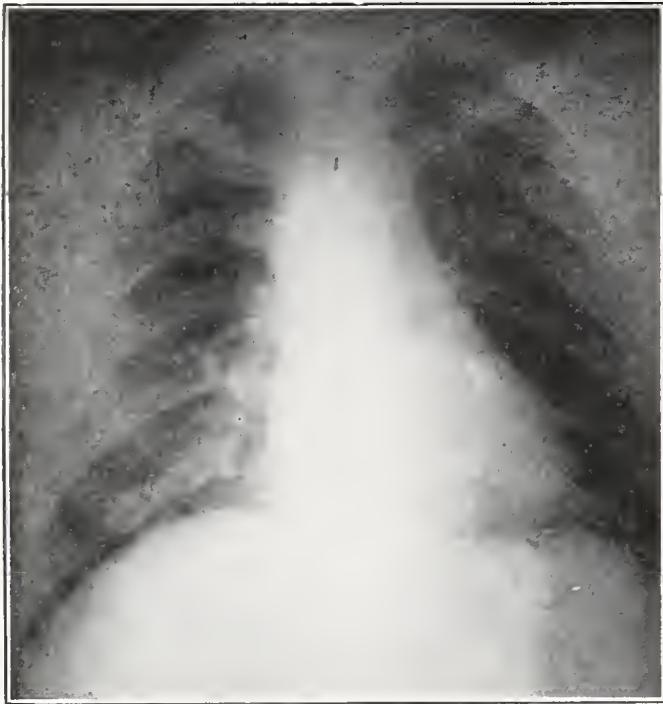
(Case 1).—Radiograph of the chest shows normal adult lung fields with moderate increase in the thickness and density of the hila and peribronchial shadows, especially in the right lower lobe.
